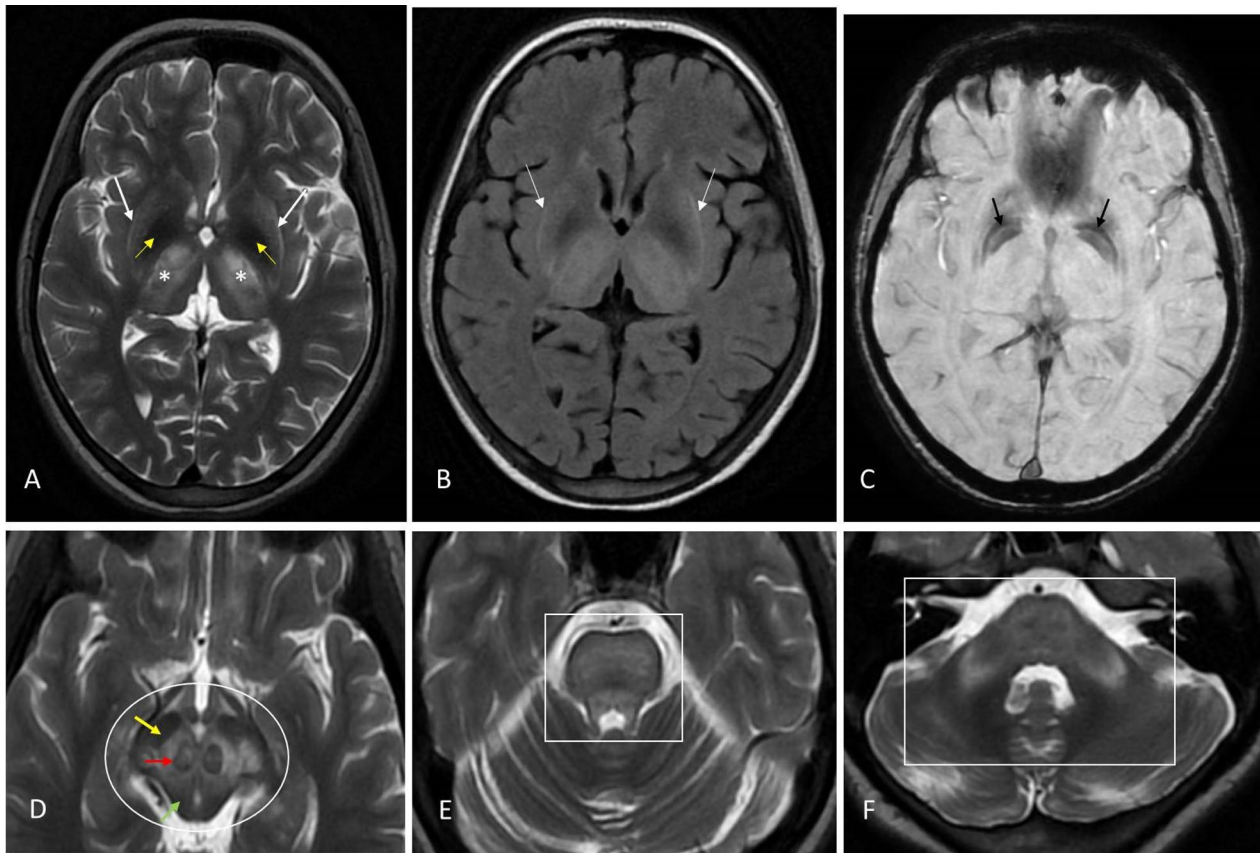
Axial T2 weighted MR image (A) and axial FLAIR MR image (B) shows symmetrical hyperintensity in bilateral putamen with thin T2 hyperintensity in claustrum (bright claustrum sign, white arrows in A and B) and bilateral thalami (white asterisks). Symmetrical hypointensity is noted in bilateral globus pallidi (yellow arrows). Axial SWAN MR image (C) shows symmetrical areas of blooming in bilateral globus pallidi (black arrows). Axial T2 weighted MR image at the level of midbrain (D) shows hyperintense tegmentum with hypointense red nuclei (eyes; red arrow), hypointense superior colliculi (chin; green arrow) and pars reticulata of substantia nigra (ears; yellow thick arrow), depicting “face of giant panda sign” (white oval). Axial T2 weighted MR image at the level of pons (E) shows hyperintense dorsal tegmentum with hypointense medial longitudinal fasciculus and central tegmental tract (eyes), hyperintense aqueduct opening into fourth ventricle (nose and mouth) and hyperintense superior cerebellar peduncles (cheeks), depicting “face of miniature panda sign” (white box). Axial T2 weighted MR image at the level of middle cerebellar peduncle (F) shows symmetrical hyperintensity in bilateral middle cerebellar peduncles (depicted by white box)
